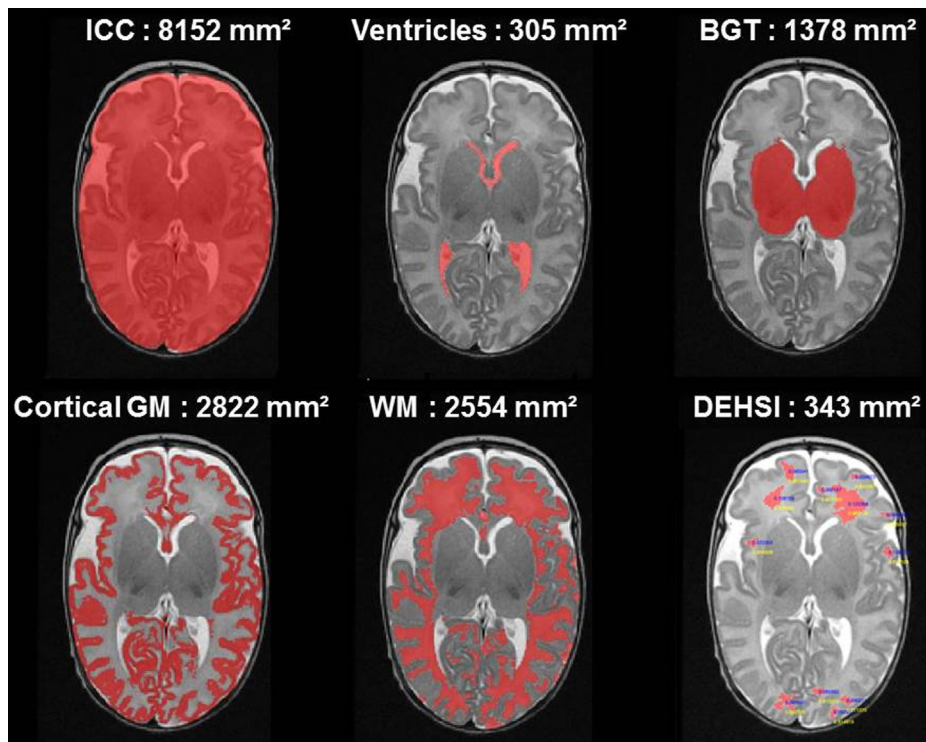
Segmented turbo spin-echo T2-weighted image in the axial plane from an included premature male, born at 31 weeks of gestation, with a weight of 1860 g. He had a transient hyaline membrane disease. Transfontanelar ultrasound examination showed normal findings. Ventricles metrics were greater than the 75th centile observed in our cohort. Age and stage questionnaire score was 210/300. ICC indicates the intracranial cavity area; BGT indicates basal ganglia and thalami area; GM indicates gray matter; WM indicates white matter; DEHSI indicates diffuse excessive high signal intensity.
